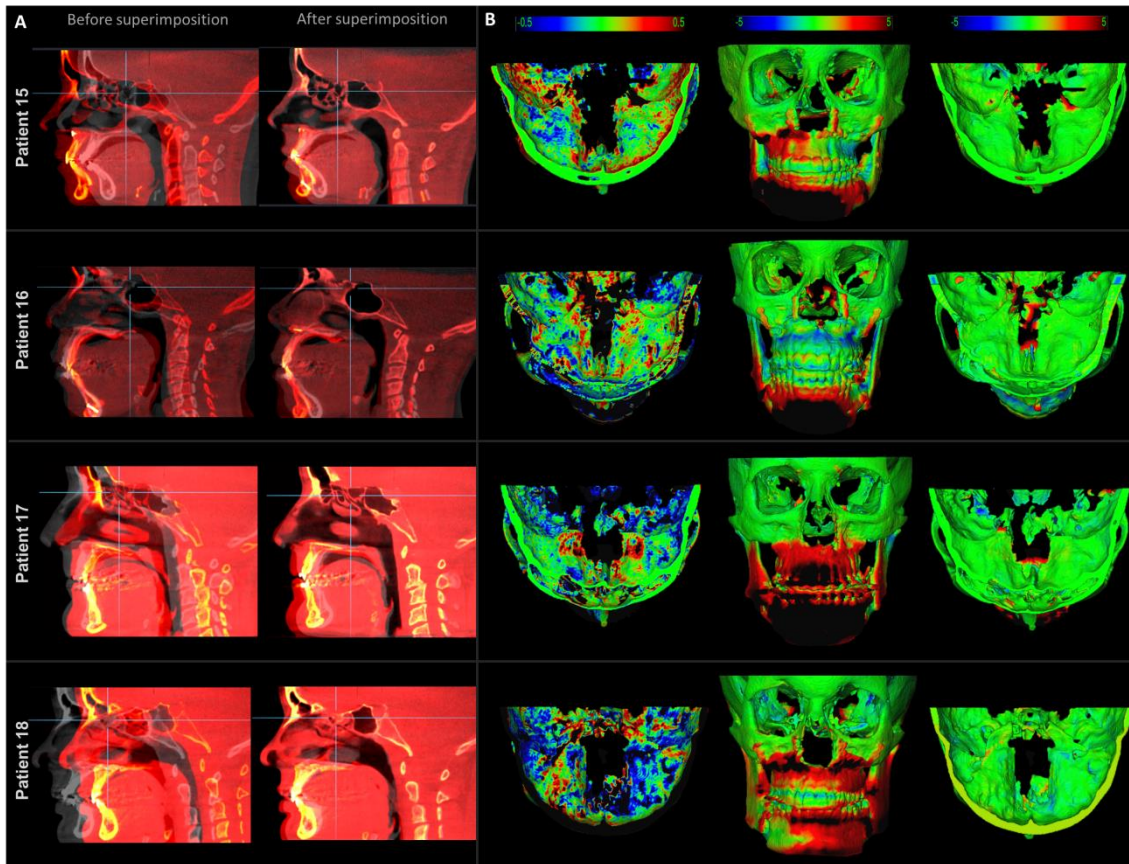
CBCT superimposition of non-growing patients subjected to orthognathic surgery with 1-year follow-up. (A) Sagittal slices view before and after cranial base superimposition in Ondemand3D. (B) 3D models after superimposition showing 3D displacements via color maps. In the 0.5mm color map, the black areas represent changes of 0.5 mm, blue/red areas represent changes less than 0.5mm and green areas represents no changes. The 5mm color map, the areas in black, red and blue are changes due to the surgical treatment. The changes at the cranial base were minimal (green) (CMF application software).
